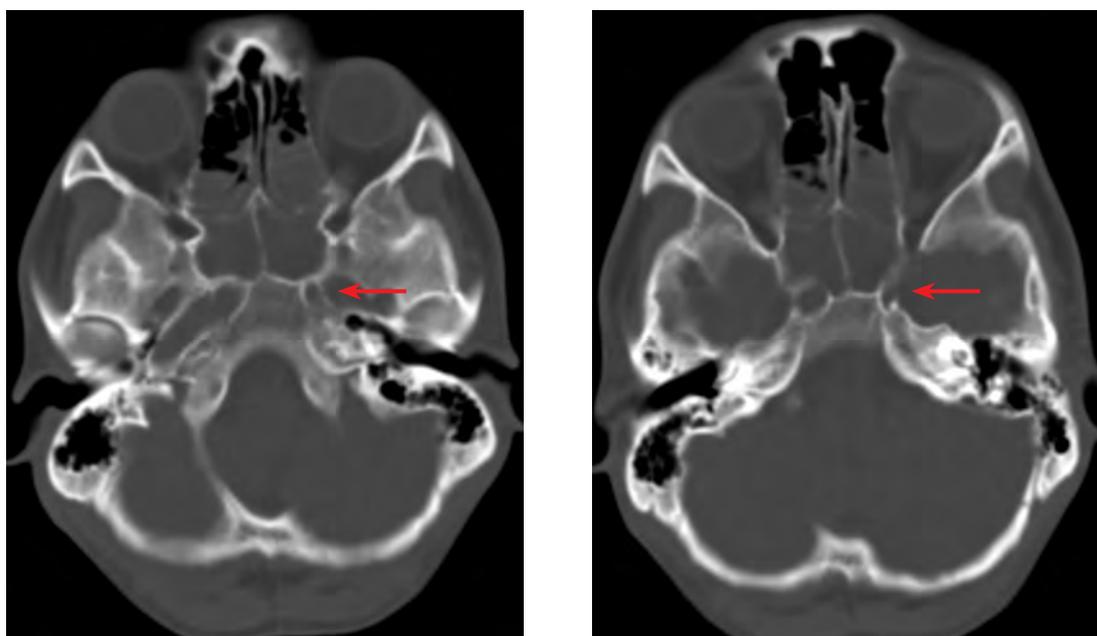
The bone window image from the axial CT scan of the skull base shows a hypoplastic left carotid canal (red arrows).
